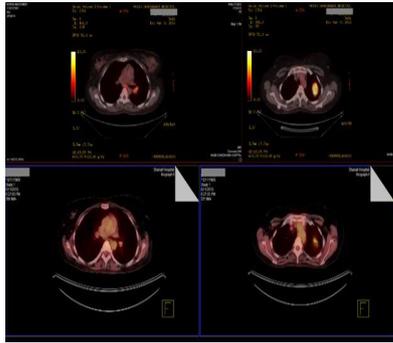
PET-CT scans of the patient at the beginning (above) and at end of combination chemotherapy (below).
